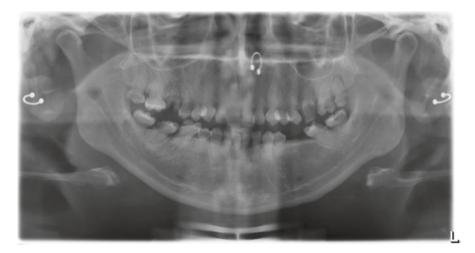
This panoramic radiograph of a 20-year-old woman with dentinogenesis imperfect type 2 shows generalized pulpal obliterations and bulbous crowns of the premolars in particular. Unfortunately she has a serious caries problem, with periapical inflammations, which makes treatment more complicated
